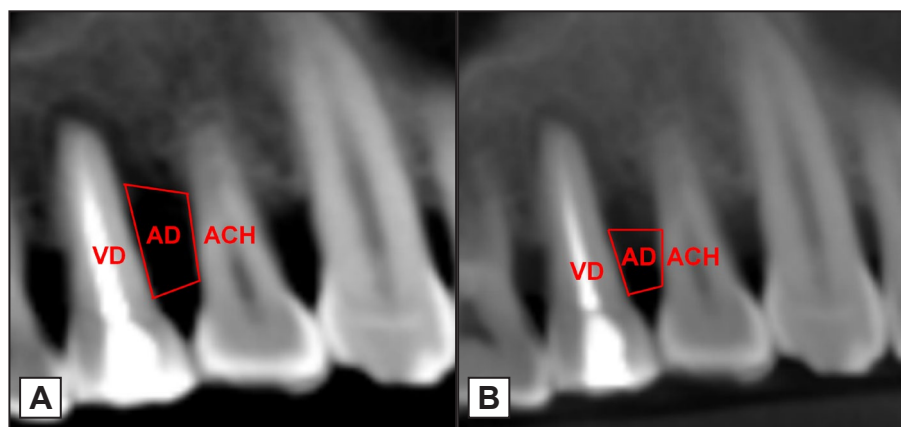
Cone-beam computed tomography measurements of vertical defect site with vertical depth (VD), alveolar crest height (ACH) and area of the defect (AD). A = at baseline; B = at 9 months.
